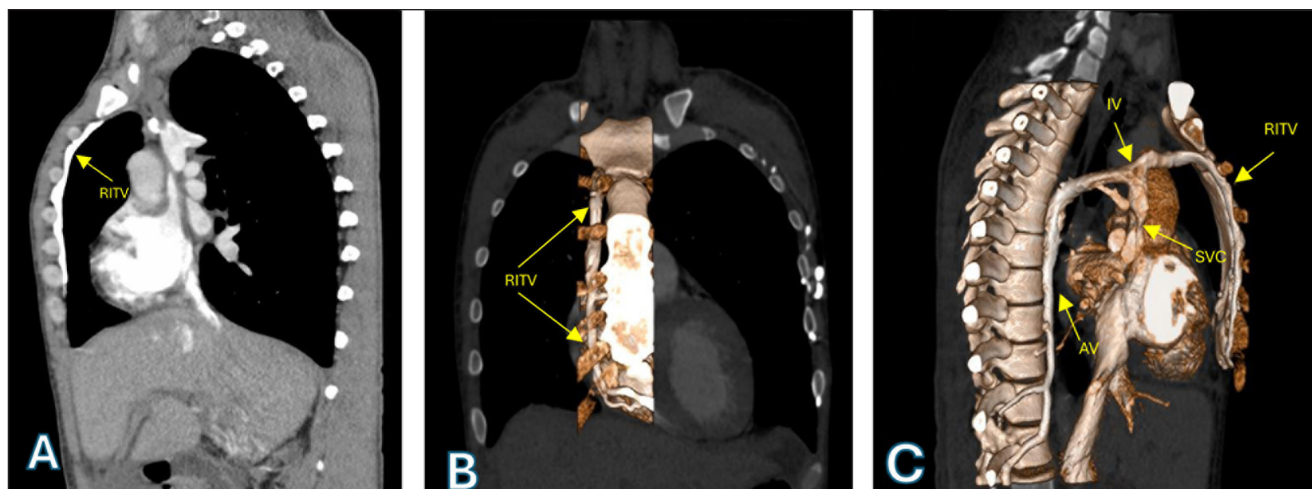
(A) Chest computed tomography angiography showing a dilated RITV. (B) 3D reconstruction showing the RITV in its parasternal course. (C) 3D reconstruction showing the remnant of the IV, the confluence of the AV, and the RITV in the SVC. RITV: right internal thoracic vein, IV: innominate vein, AV: azygos vein, SVC: superior vena cava
